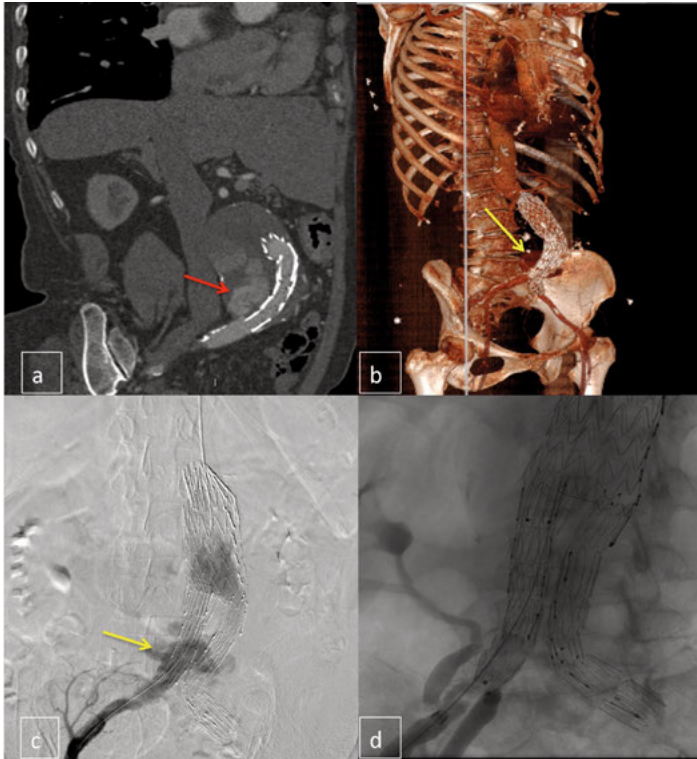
Right side Endoleak Type Ib on CTA (a and b) and DSA (c), management with limb extension (d).
